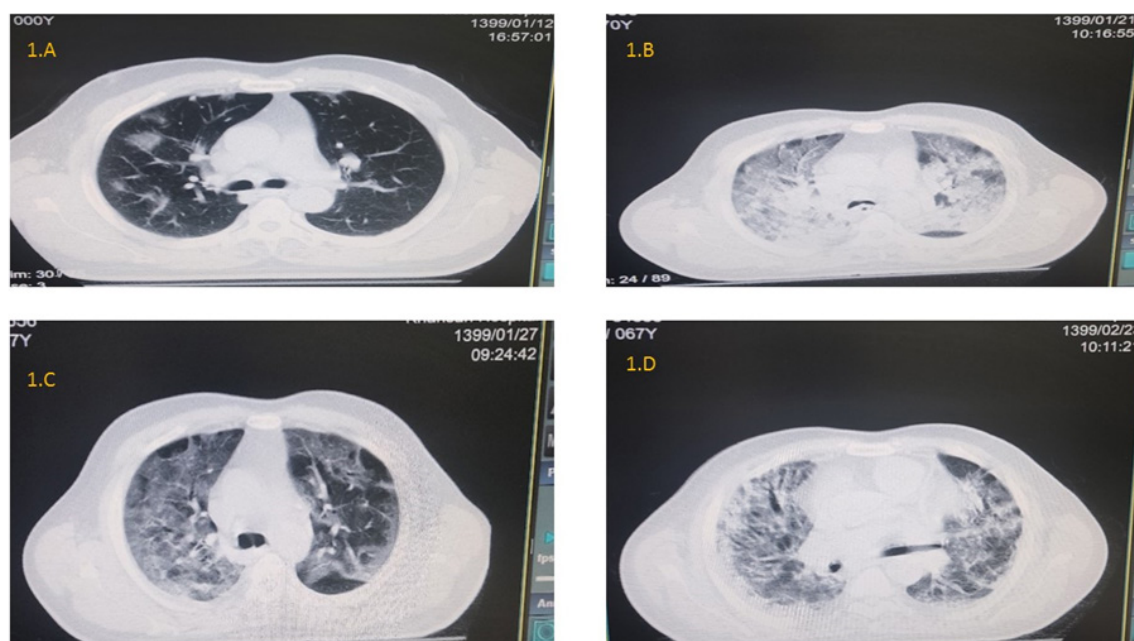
Infections (1.A- 1.D). 1.A Chest CT: Peripheral ground-glass opacities (GGO) in both lungs with predominance in the right lung. 1.B Chest CT: GGO (crazy-paving pattern) and centrilobular nodularity in both lungs. 1.C Chest CT: Predominance GGO in both lungs with desquamative interstitial pneumonia and patchy consolidation, a vascular prominence in the left lung, and distribution of spermatocoeles. 1.D Chest CT: peripheral GGO with desquamative interstitial pneumonia, centrilobular nodularity in the right lung.
